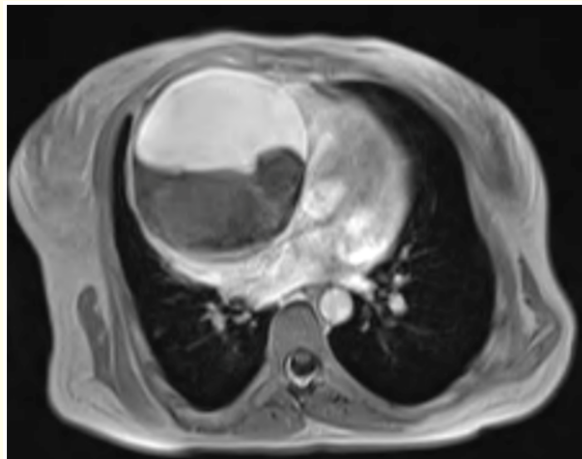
Axial MRI in T1 sequence showing the same giant right coronary artery aneurysm, partially thrombosed.
